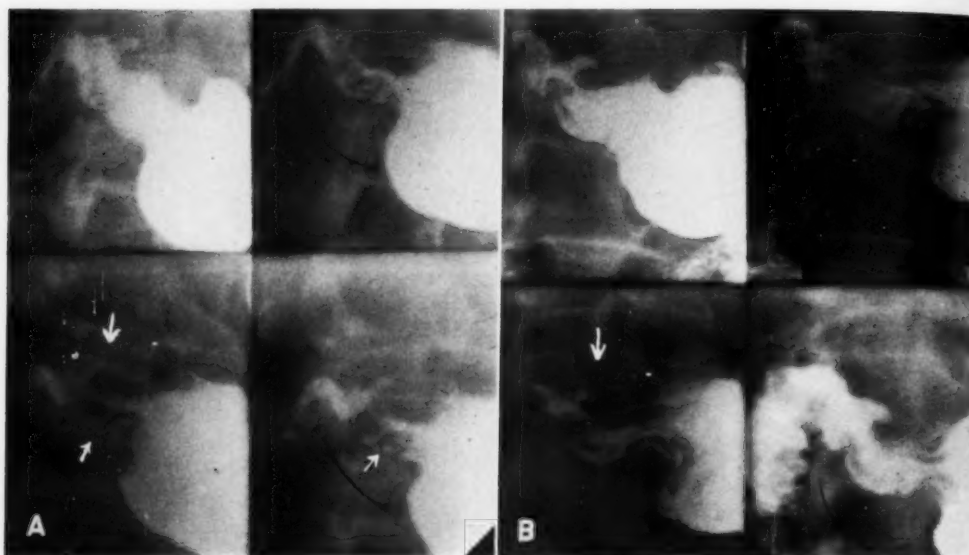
Case III. Male aged 59. Example of an error on the part of the family doctor in not obtaining earlier x-ray examination.
